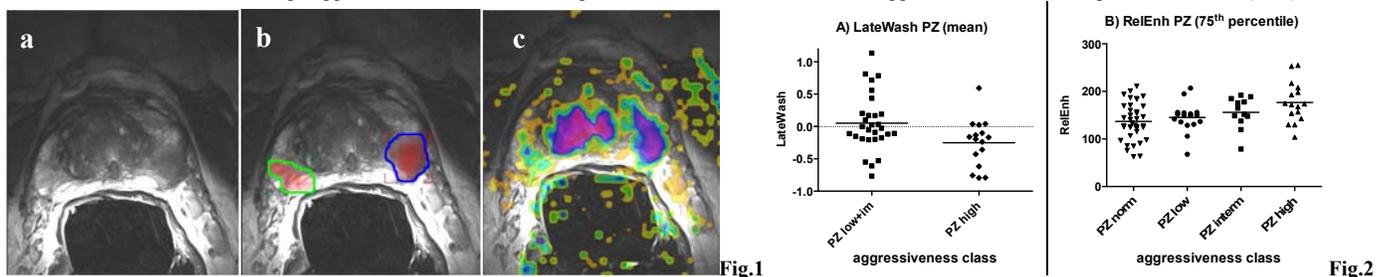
Axial T2-w MRI of the prostate of a 65-year-old man with Gleason 4+5 PCa (=highly aggressive). a) T2-weighted image with PCa in the left PZ, b) ROI in blue line covering PCa, ROI in green line covering non-cancer tissue of the PZ, c) K^{trans} overlay on T2-weighted image, enhancement of the PCa region in the left PZ and less enhancement of non-cancer prostate tissue. Fig. 2. Non-cancer tissue parameters for a) LateWash (mean) low aggressive PCa and combined intermediate/ high aggressive PCa, b) Relative Enhancement (75th percentile) low aggressive PCa, intermediate aggressive PCa and high aggressive PCa.
